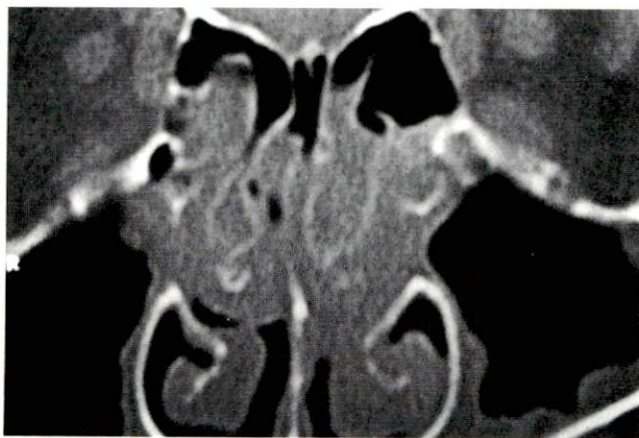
CT scan reveals ostiomeatal complex disease disproportional to maxillary sinus findings.
